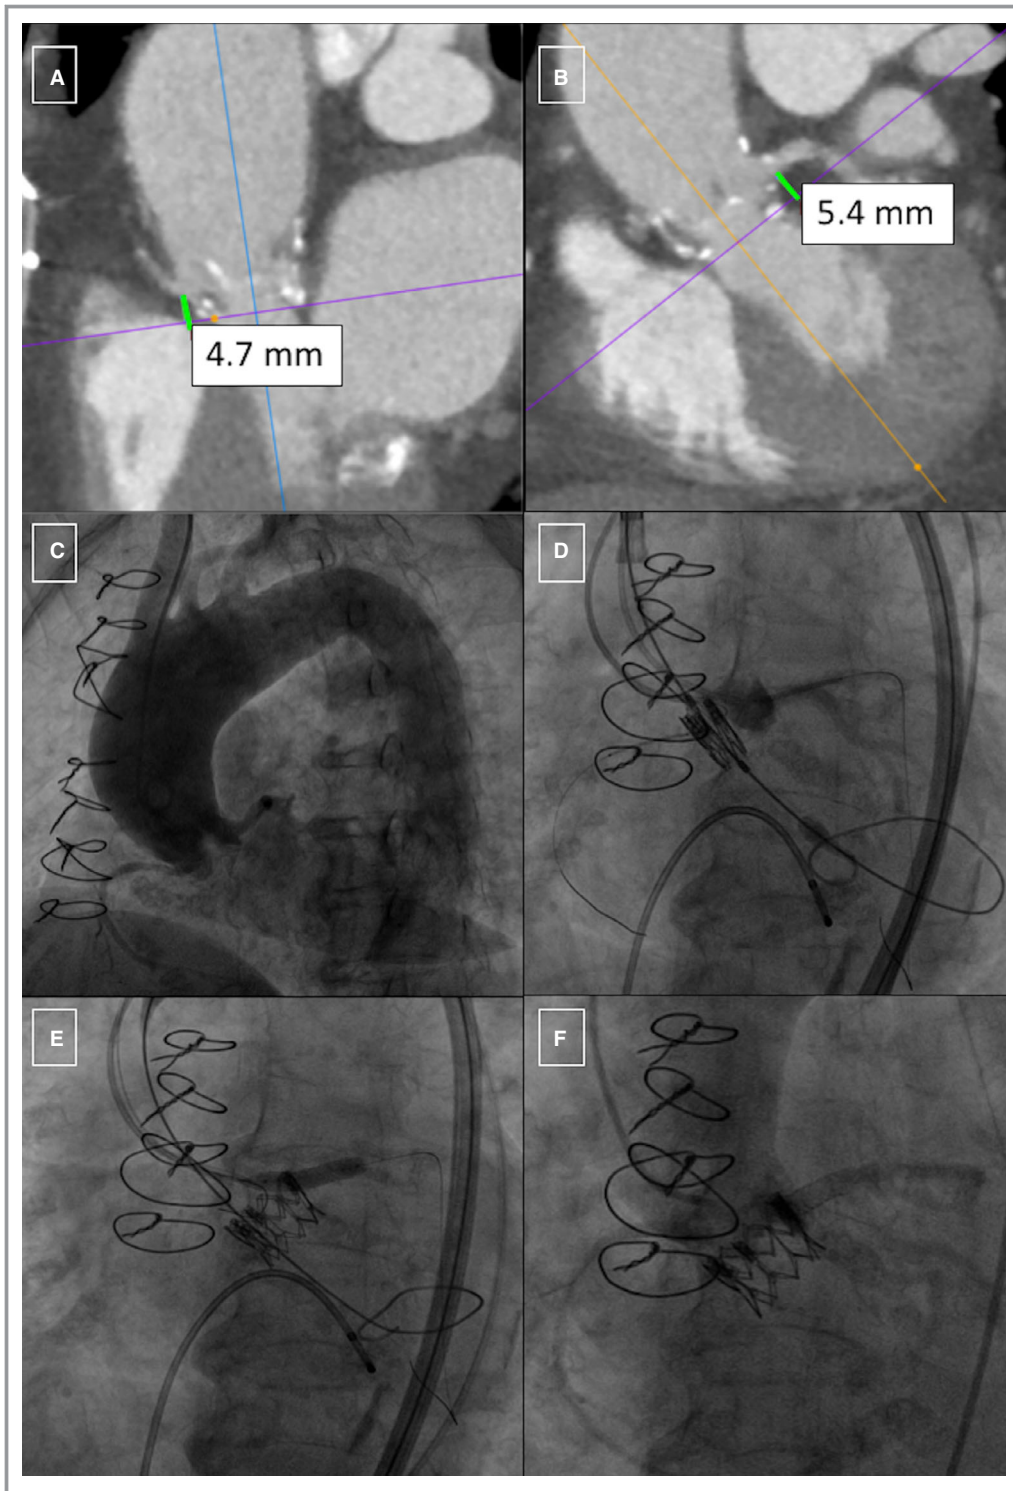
Preventive strategies to avoid coronary occlusion in a high risk valve-in-valve procedure. This case shows the wire and jailed stent protection technique in a patient with a degenerated Sorin Freedom stentless 23 mm valve (A through C). Baseline multidetector computed tomography and angiography showed the low bilateral coronary takeoff. An undeployed stent was prophylactically positioned in the left main stem (LMS) before advancing a Sapien XT 20-mm valve (C and D). Immediately after valve deployment, the patient’s hemodynamics crashed and the coronary stent was inflated at high pressure in the LMS at the ostial position (E). The final aortogram showed the Sapien-XT valve in correct position and widely patent coronary arteries (F). Reprinted from Maggio et al⁵⁹ with permission. Copyright ©2017, Oxford University Press.
